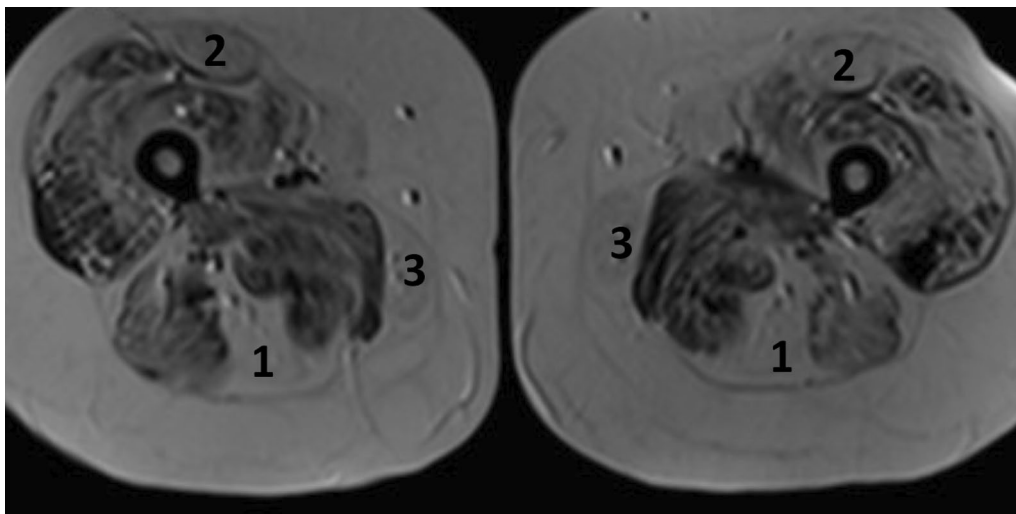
Axial T2-weighted muscle MRI of the upper part of the lower limbs showing fat infiltration and fibrosis affecting all compartments with the most pronounced involvement of the semitendinosus and semimembranosus (1), rectus femoris (2) and gracilis (3) muscles
